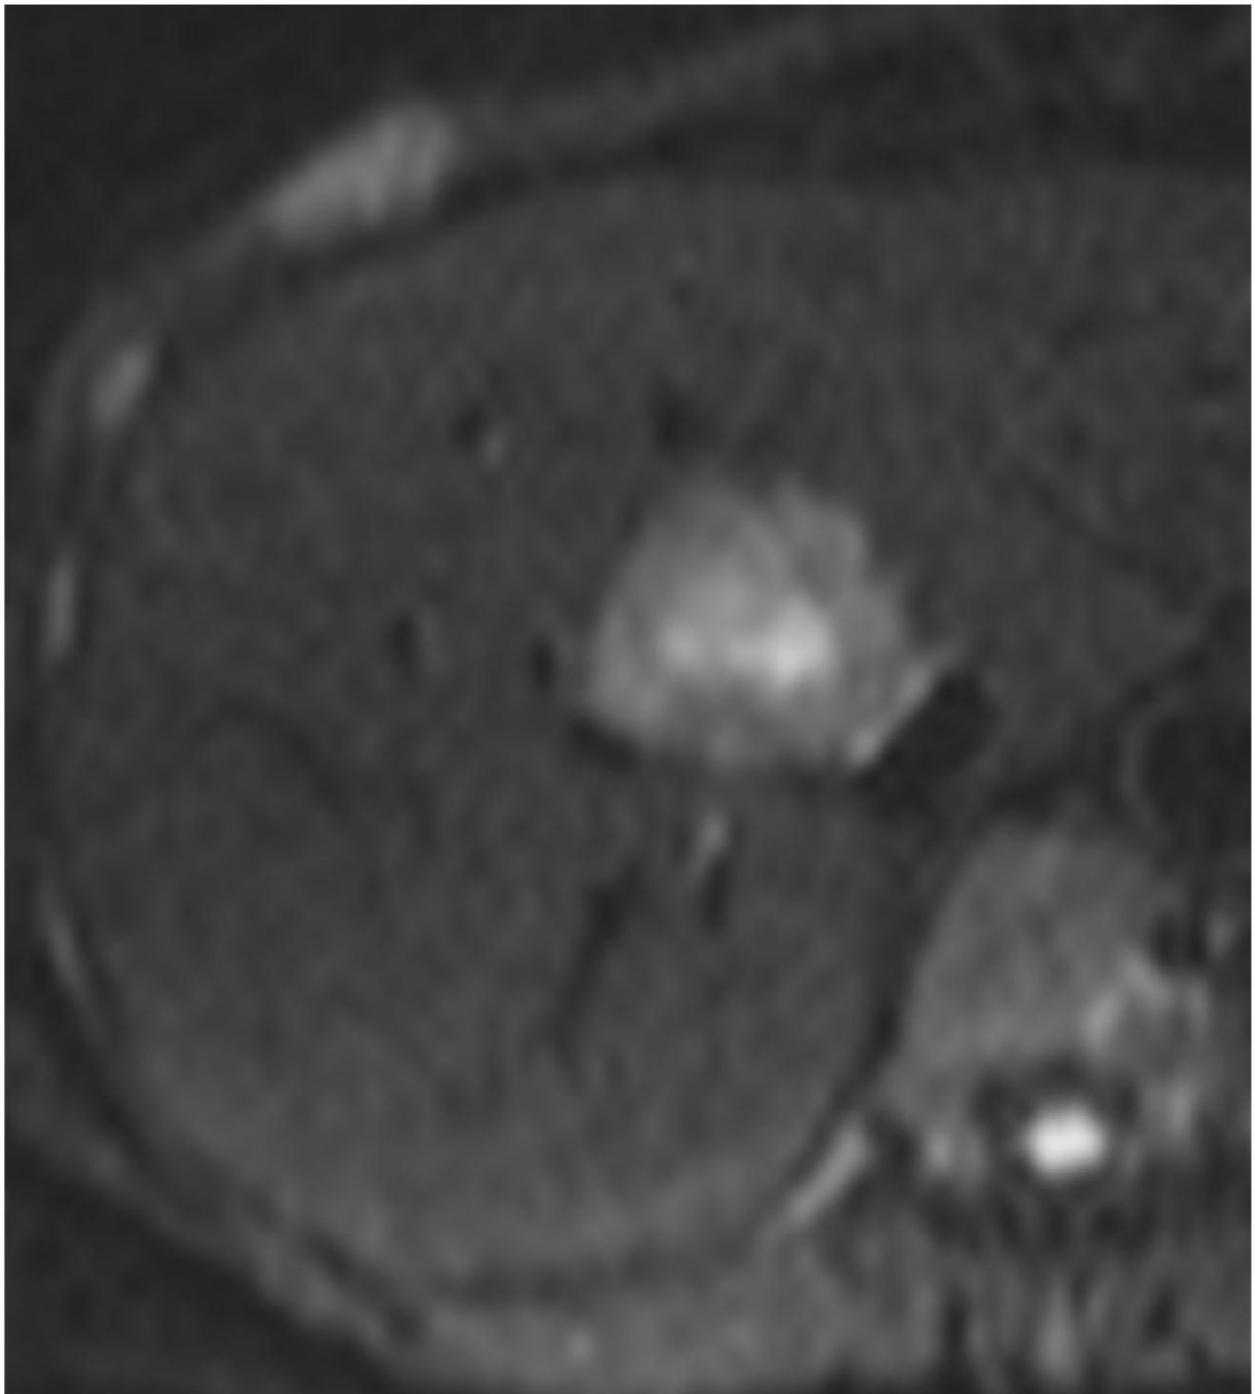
Diffusion-weighted MRI, b-value=50. The same female patient. FNH shows restricted duffusion.
